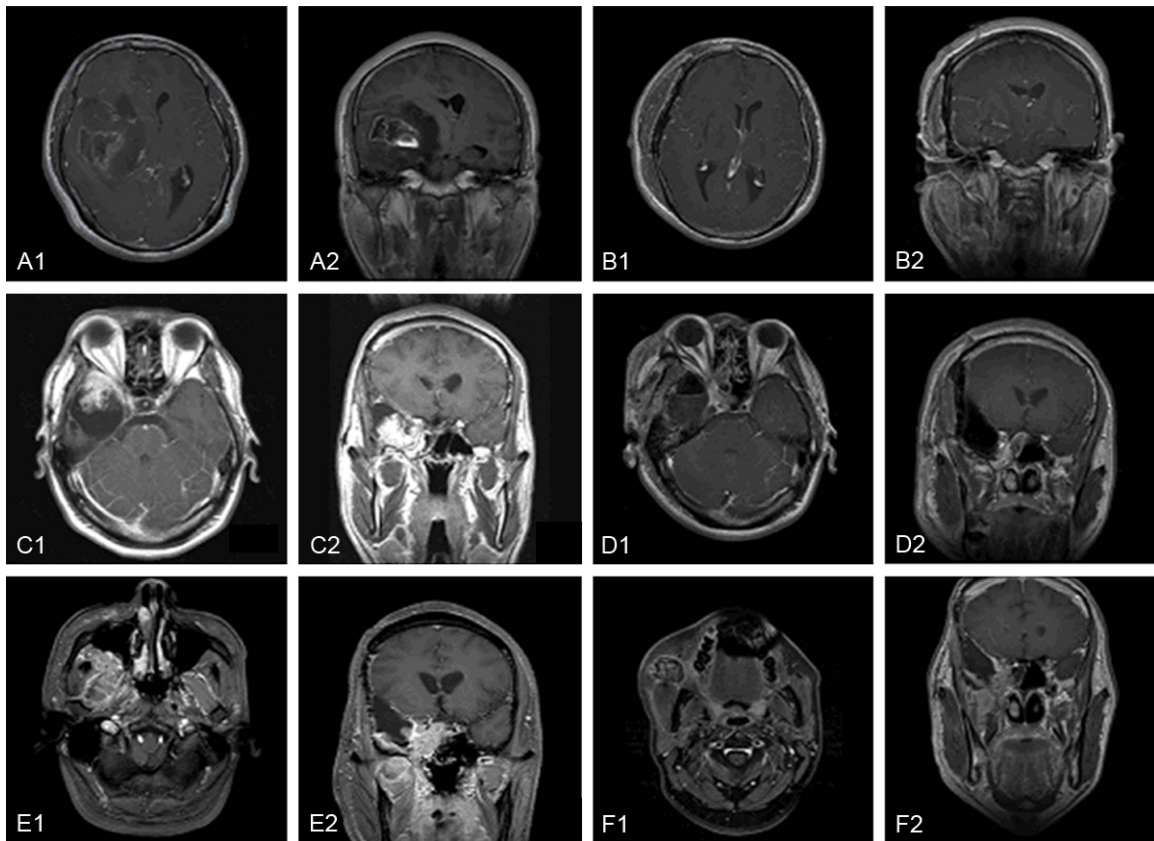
A1 and A2: MRI images before the first operation; tumor with bleeding located in the right temporal lobe. B1 and B2: MRI images after the first operation; tumor was completely resected and the ventricular was not entered. C1 and C2: MRI images before the second operation; heterogeneously enhancing lesion in the right temporal lobe revealed the tumor recurrence the first time in situ. D1 and D2: MRI images after the second operation; tumor was completely resected again. E1 and E2: Tumor recurrence the second time with extracranial extension to the right musculus pterygoideus and the maxillary bone and invasion of the sphenoid sinus and right orbital cavity. F1 and F2: The extracranial tumor developed and involved right zygomatic arch.
